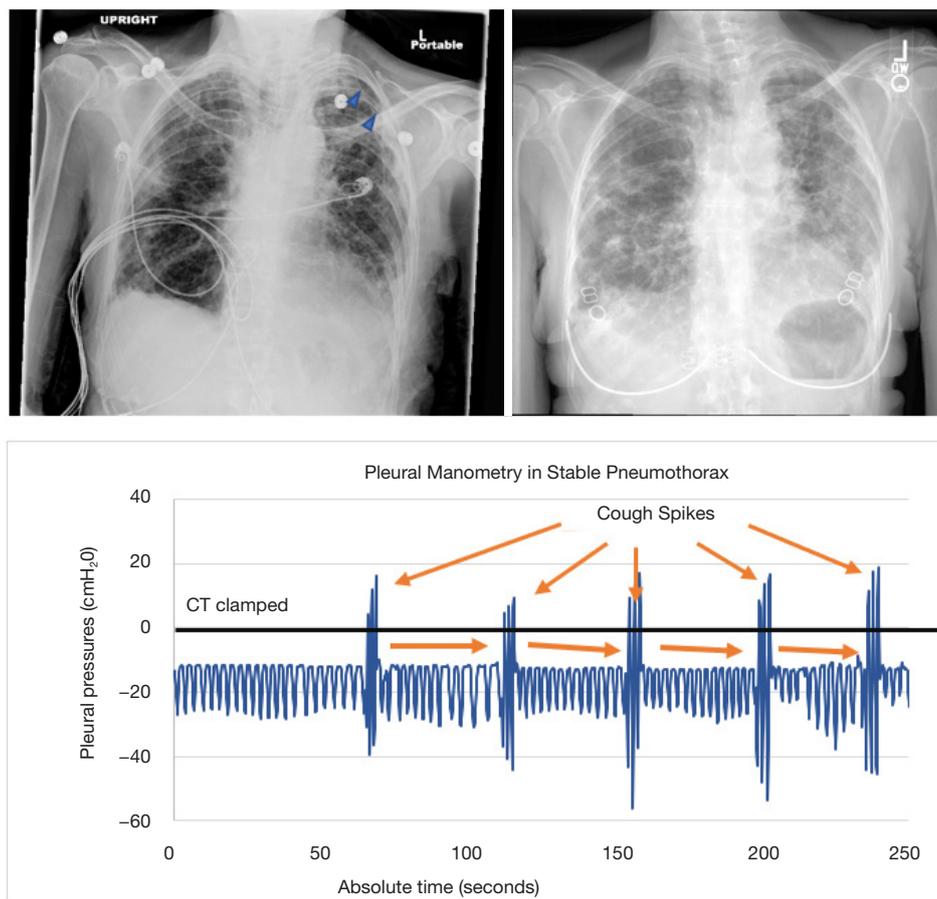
Radiographic finding and PM tracing of a stable pneumothorax. The left CXR shows a small apical pneumothorax when this patient first presented to the hospital. The right CXR was taken 30-days post chest tube removal which shows the pneumothorax space replaced by a pleural effusion. The PM tracing shows a typical pattern of a stable pneumothorax. PM, pleural manometry; CXR, chest X-ray.
